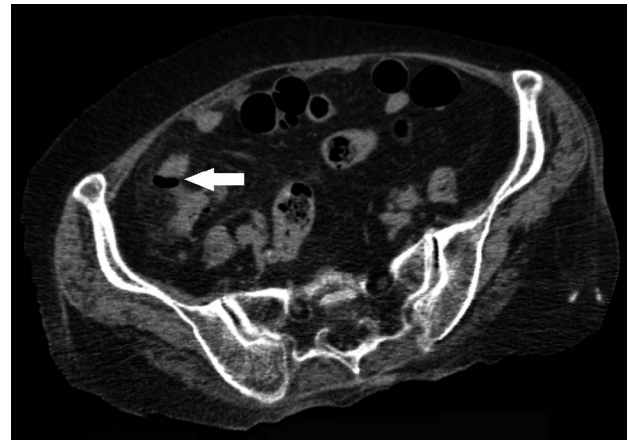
CT of case 3 indicates pericolic fat infiltration and air loculation in right low quadrant (arrow).
